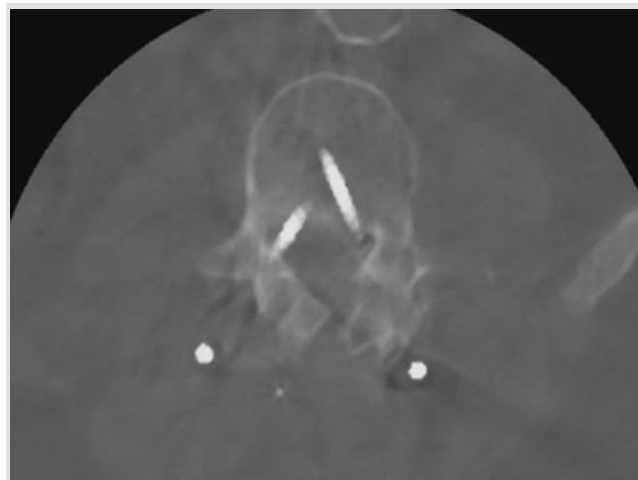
A computed tomography scan image after the initial decompression of L2 and L3 and a posterior spondylodesis Th12-L5 showing a medial position of both L4 screws.
